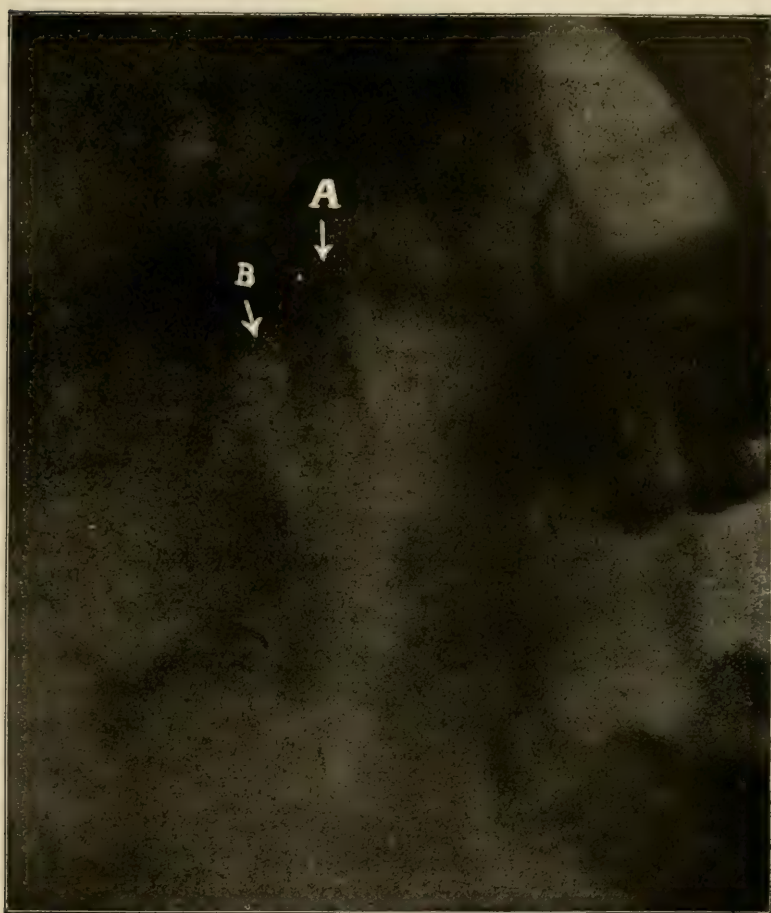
Dislocation of the condyle from the glenoid fossa. A, condyle. B, eminentia articularis. (Radiograph by Cole and Raper.)
